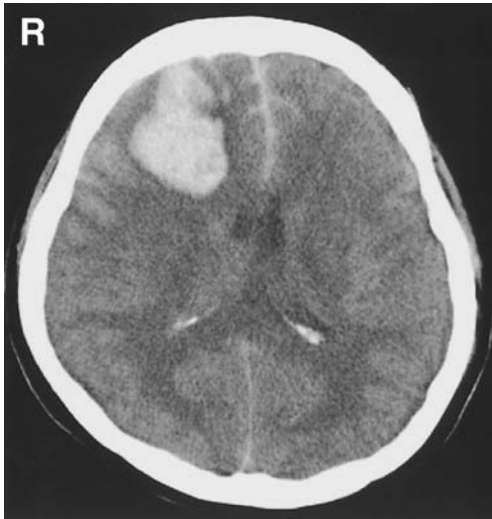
Computed tomography scan performed immediately after cesarean section showing intracerebral hemorrhage in the right frontal lobe.
